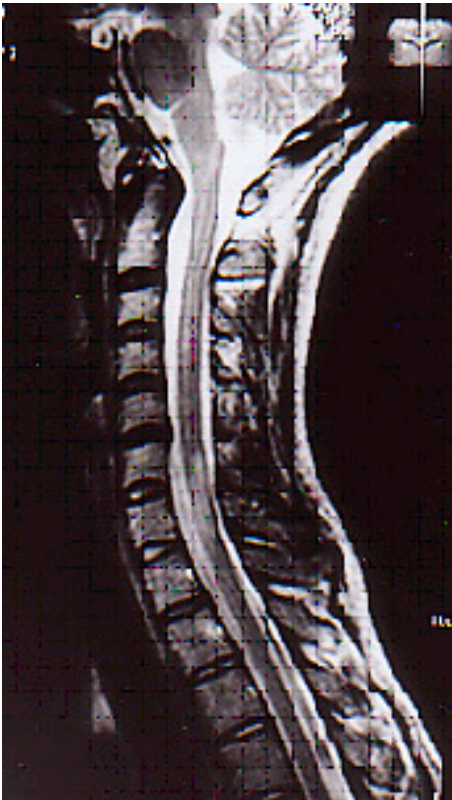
Patient with severe relapsing remitting course of MS, died in two years from onset. Spinal cord MRI showed typical small posterior demyelinating lesions, not extending over the entire diameter of the spinal cord.
